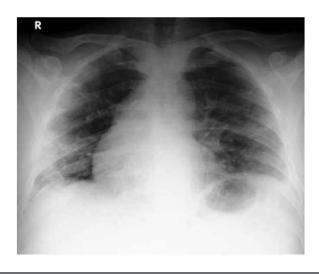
A chest X-ray (CXR) showed multifocal patchy peripheral consolidations in the middle and lower zones of both lungs, especially in the right lung. The Brixia score of the CXR was I4. (The right lung score was 7, and the left lung score was 7.)
